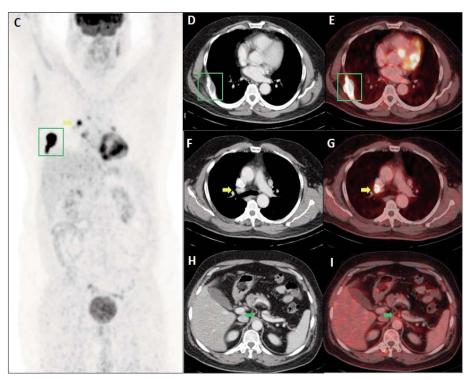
Planar 99mTc MDP bone scan anterior [A] and posterior [B] images show avid expansile right 7th rib lesion (green box) and faint uptake in left 4th rib (blue arrow). Maximum intensity projection (MIP) image of 18F FDG PET-CT shows hypermetabolic right 7th rib lesion [C, green box] and mediastinal nodes [C, yellow arrow]. No uptake in the left 4th rib was noted. Right 7th rib uptake correlated to a lytic lesion with soft tissue on SPECT/CT [Axial CT only D and fused SPECT/CT E, green box]. In addition, avid dense appearing nodes on SPECT/CT were seen; likely reactive [F, G yellow arrows]. FDG avid tiny para-aortic node was noted [H,I green arrows].
